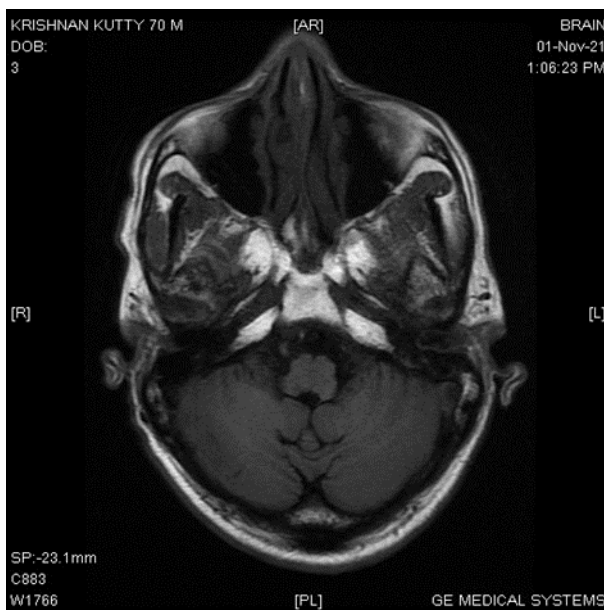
MRI -Infarct right medulla extension
